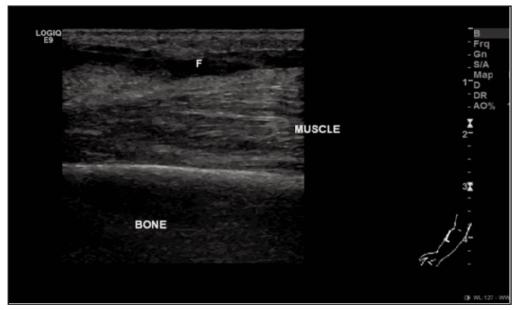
Ultrasonography image showing a fluid collection between subcutaneous tissue layer and fascia.
